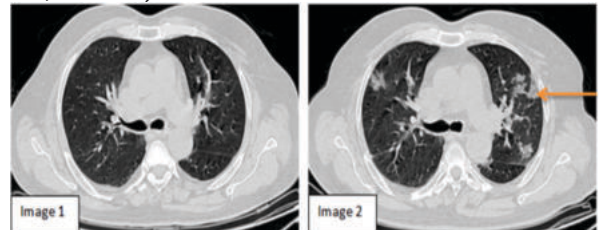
Axial HRCT Thorax Images of 52 year old male Patient Image 1: On day 3, Minimal changes noted on HRCT (CRP -9, CT Severity score-0). Image 2: On day 9, GGOs opacities in left posterior segment of upper lobe and apical segment of Lower lobe (Arrow) (CRP-23, CT severity score-7) (WL:-450, WW:1500)
